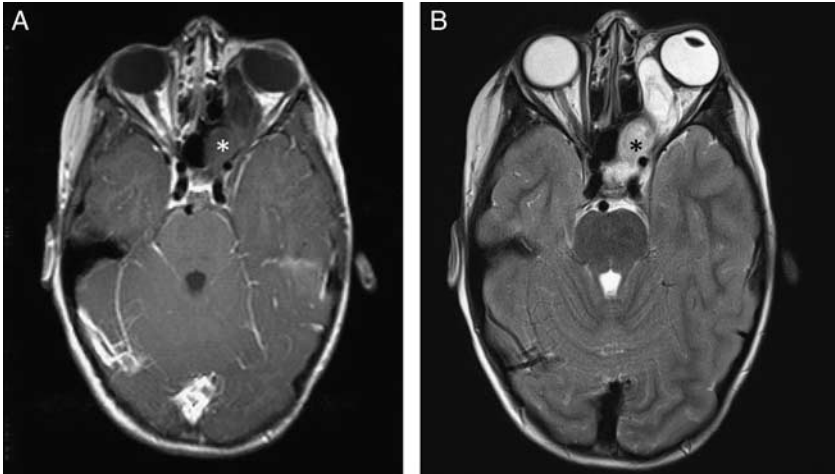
9-year-old girl was diagnosed with an optic glioma (pilocytic astrocytoma) after she was noted to have a left gaze preference. Genetic testing for neurofibromatosis I was negative. Axial T1-weighted postcontrast fat-saturated MRI demonstrates an isointense peripherally enhancing mass extending from the posterior optic chiasm into the left optic nerve and medial left orbit (A, white asterisk). Axial T2-weighted MRI demonstrates the mass to be heterogeneously T2 hyperintense (B, black asterisk). MRI indicates magnetic resonance imaging.
